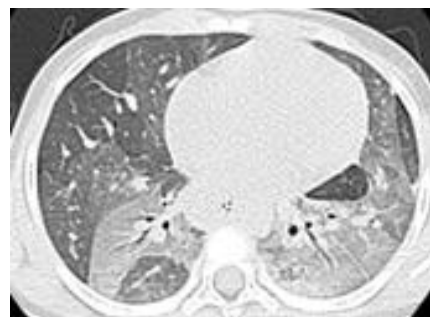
HRCT features of desquamative interstitial pneumonia (DIP)
